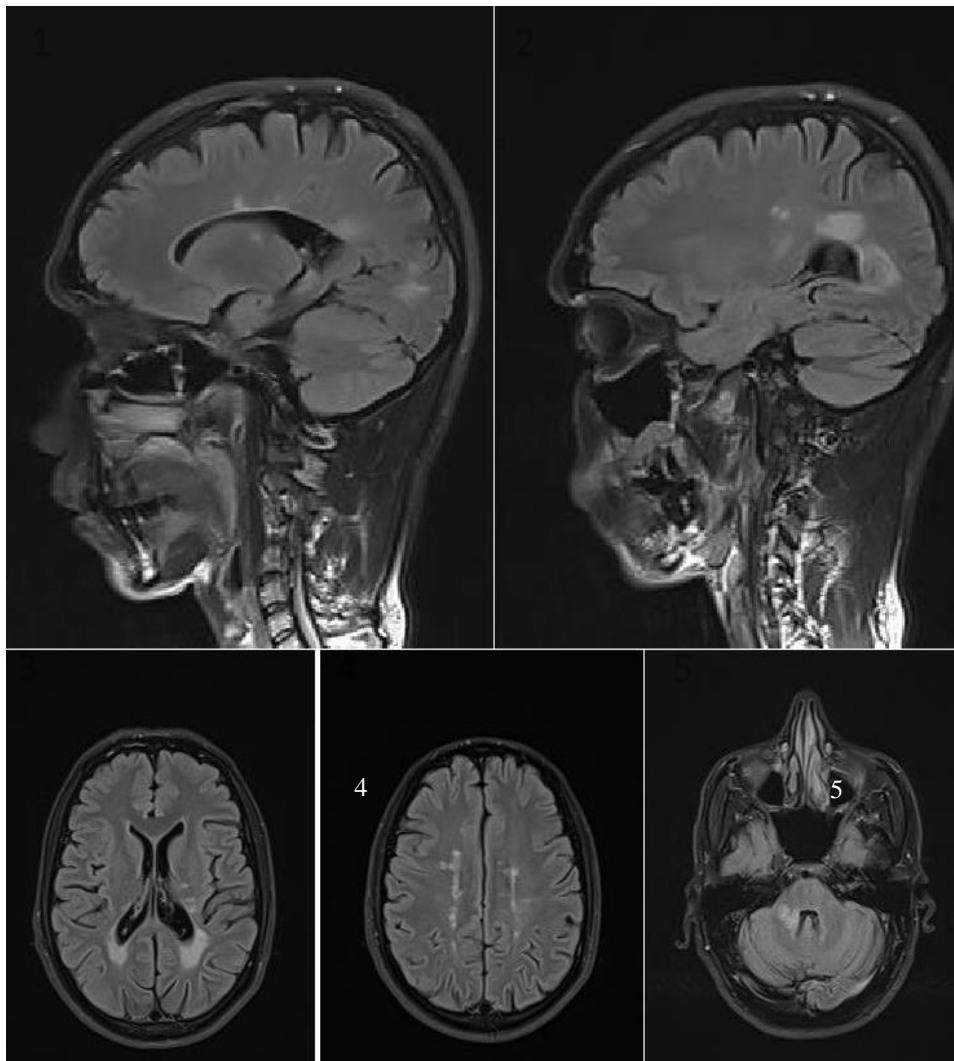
Sagittal view of FLAIR MRI . Figure 3,4 and 5 : axial slices of FLAIR MRI showing demyelinating lesions in the supra- ,sub tentorial and periventricular regions
